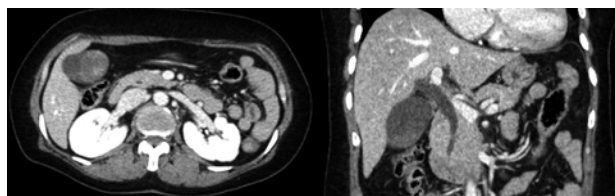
Abdomen CT scan 2 years ago.
